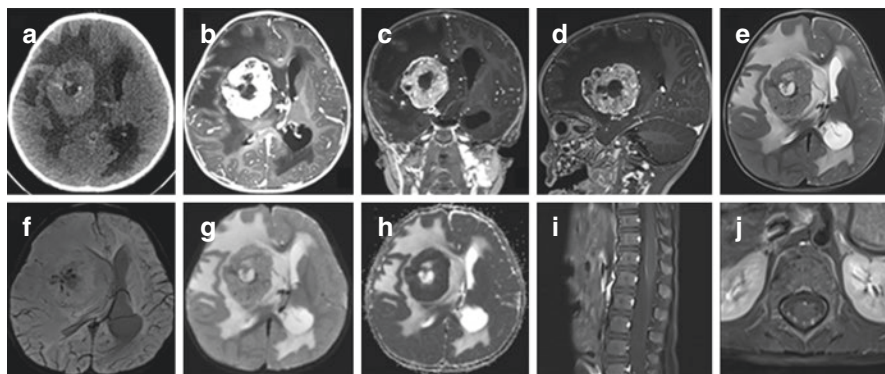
CT and MRI brain of ETMR. (Patient example from our institution, Neurosurgical Service, KK Women's and Children's Hospital). Neuroimaging demonstrating a moderately large heterogeneously enhancing lesion arising from the right external capsule with internal haemorrhage and restricted diffusion. Representative spine image of the same patient demonstrating a leptomeningeal enhancement suspicious of a drop metastasis. (a) Axial CT image; (b–d): Axial, coronal and sagittal T1 + C; (e): Axial T2W image; (f) Axial GRE image; (g–h) Axial DWI and ADC images; (i–j) Sagittal and axial T1W + C whole spine. (CT: computed tomography; MRI: magnetic resonance imaging; EMTR: embryonal tumour with multi-layered rosettes; T1W + C: T1 weighted with contrast; GRE: gradient echo; DWI: diffusion weighted image; ADC: apparent diffusion coefficient)
